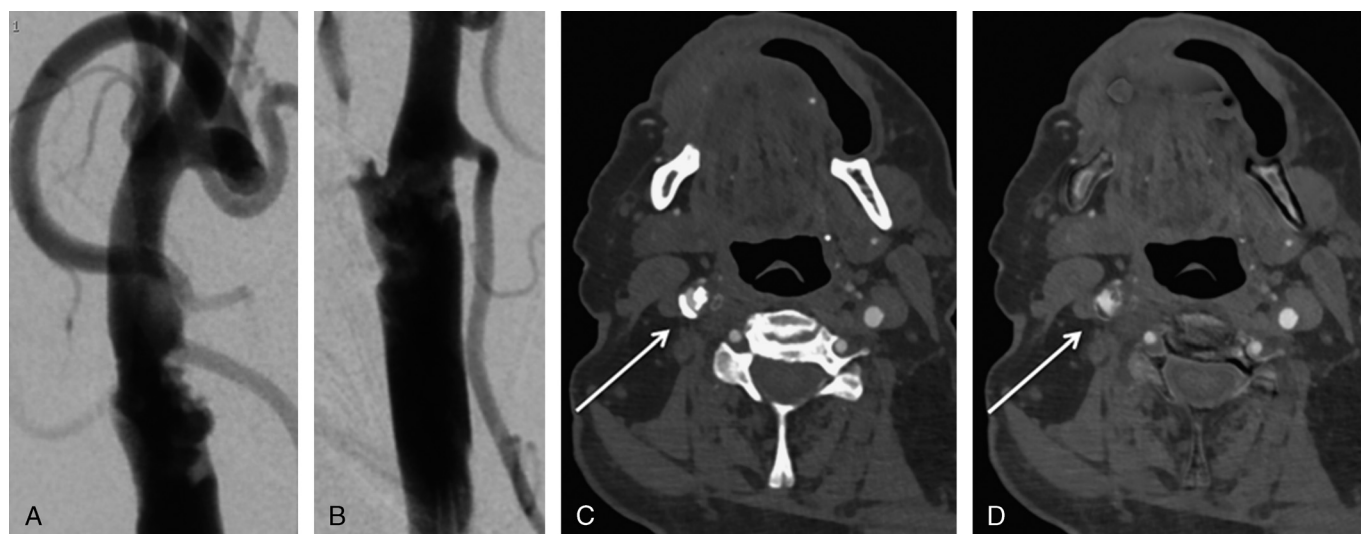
A 74-year-old man with calcified stenosis (22%) of the right common carotid artery. A and B, Digital subtraction angiography in coronal and sagittal projection. C and D, Axial mean computed tomography angiography (left) versus axial virtual noncalcium imaging (right) at the location of maximum calcified carotid artery stenosis (arrow).
